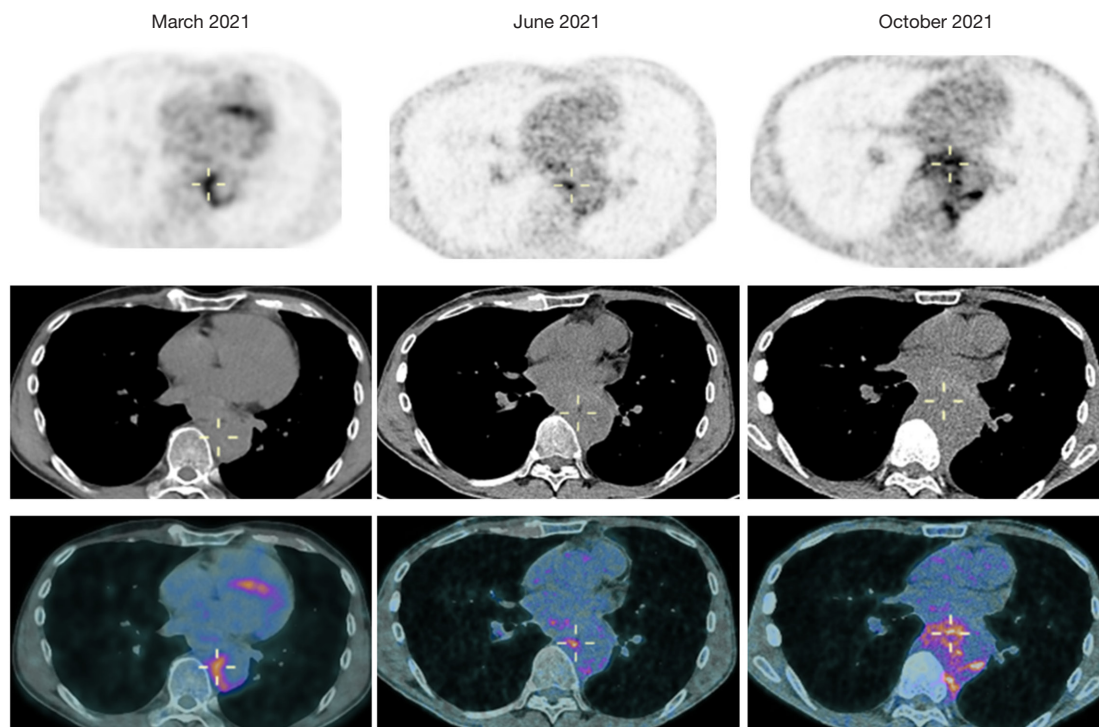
^{18}F FDG PET/CT images showing partial response at distance from the cryoablation site. ^{18}F FDG PET/CT, ^{18}F fluorodeoxyglucose positron emission tomography/computed tomography.
